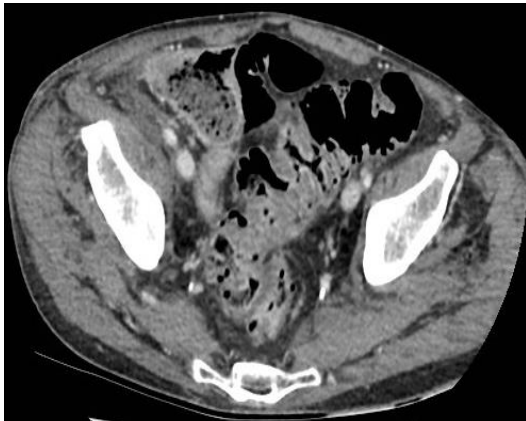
Portal venous phase CT showing segmental sigmoid colon thickening.
